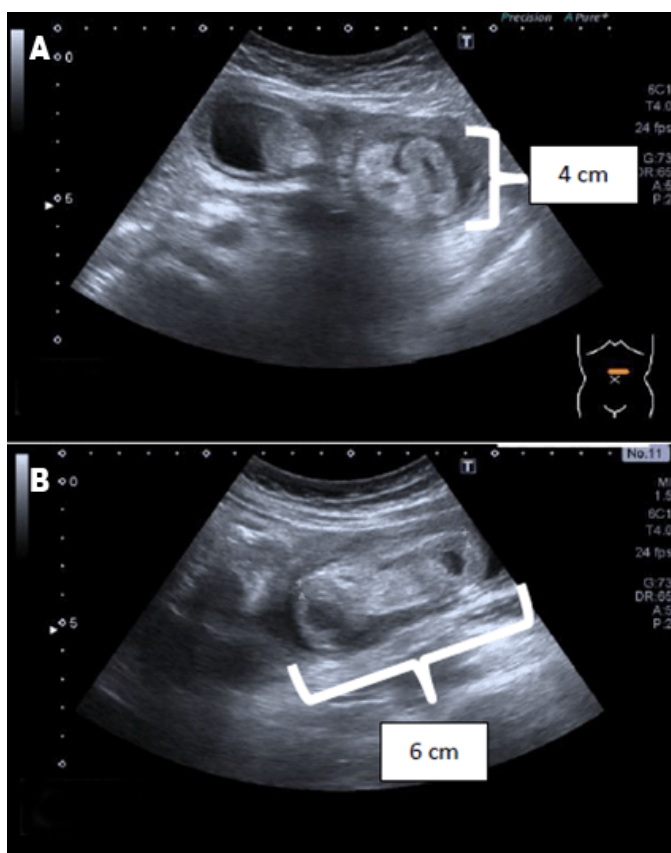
Ultrasonography showed target sign located at mesogastrium and left flank. (A) Diameter of the lesion was 4 cm, (B) Length of the lesion was 6 cm.
